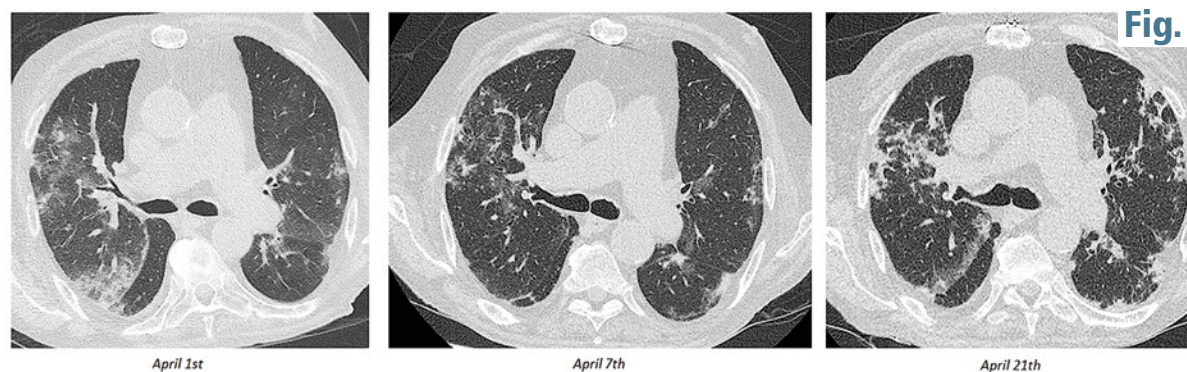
Moderate GGO and alveolar consolidations on initial Chest CT at D7, evolving towards reticulations at D14 and with pattern of organising pneumonia and traction bronchiolectasis at three weeks. Whether these lesions will completely resolve or not at further follow-up is still unknown
